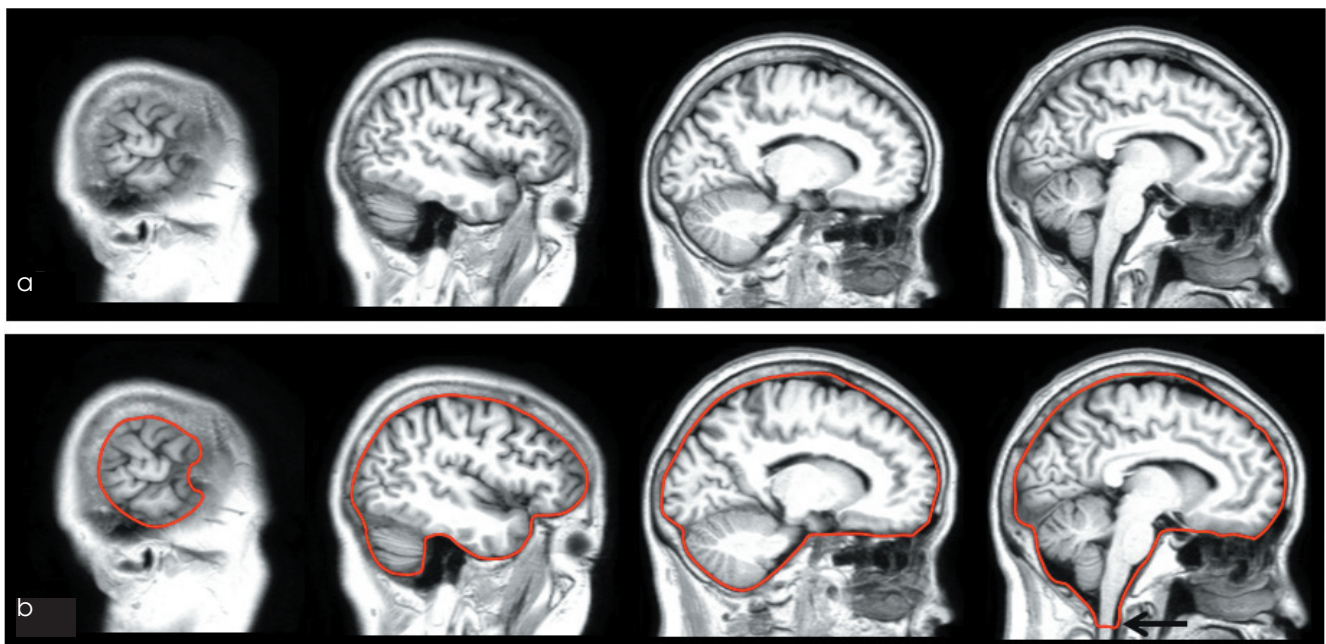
The Boundary determination of ICV. Using 5-mm thickness sagittal MRI which was reconstructed from 1.3-mm thickness coronal MRI (a), the outer boundary of ICV was manually traced on the dura mater (b), and the lateral limits were defined as the most lateral slices of the brain parenchyma. The lower tip of the cerebellum was defined as the lower limit, and to establish the inferior boundary on the head tilt-corrected sagittal images, a horizontal line was drawn across the midbrain to include the lower tip of the cerebellum (black arrow).
